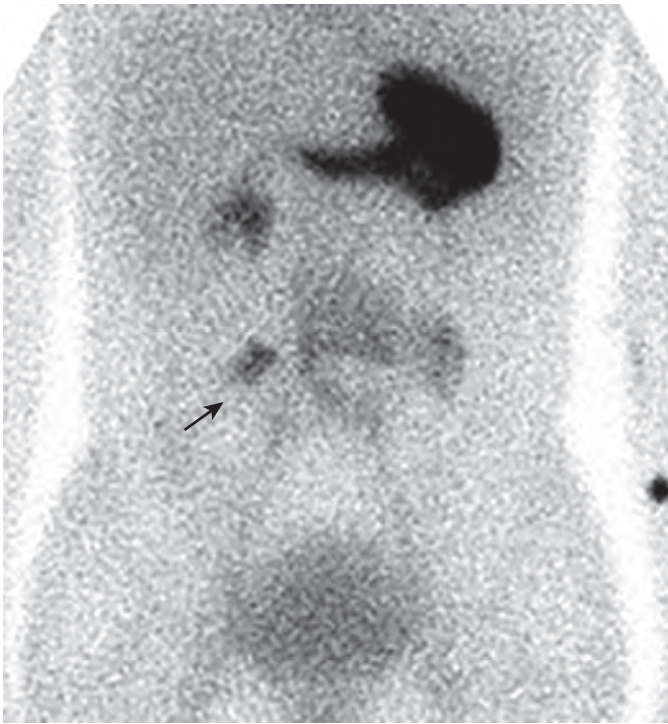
Meckel's diverticulum: nuclear scintigraphy. Technetium pertechnetate has passed from the stomach into the proximal small bowel. A small region of abnormal and persistent activity in the right lower quadrant (arrow) represents isotope localizing within ectopic gastric mucosa within Meckel's diverticulum.
